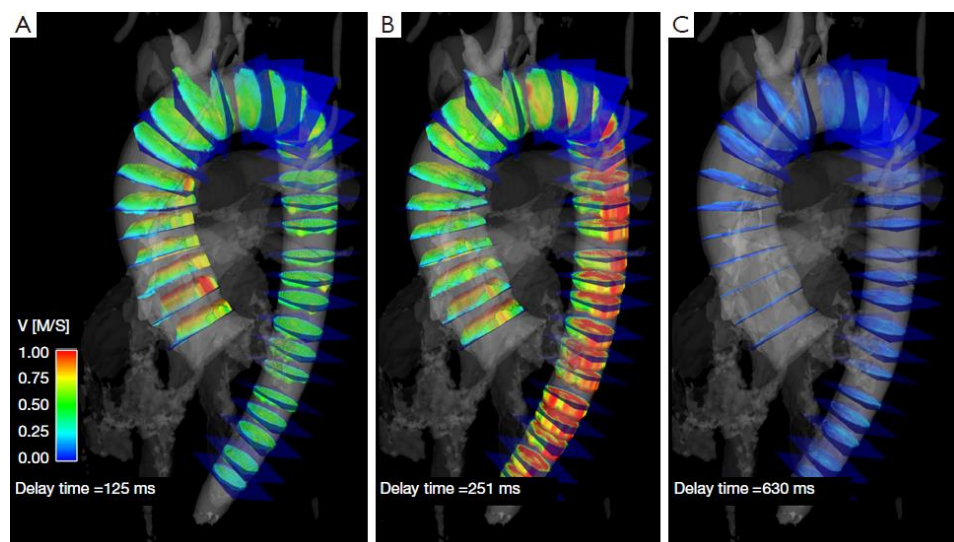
9 Example of aortic flow data acquired with 4D Flow MRI for PWV measurement. Reproduced from [98] with permission.
